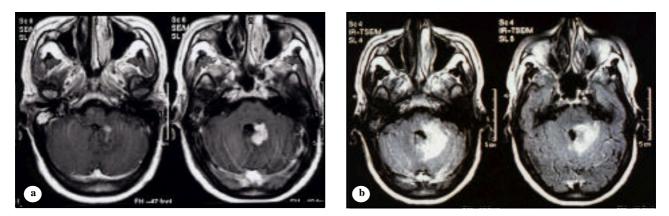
Magnetic resonance imaging of brain showing a) Axial fast flair sequence showing increased signal intensity involving the left middle cerebellar peduncle, extending to the left side of the pons. High signal in the right mastoid bone. b) Axial T1 post contrast injection, demonstrating enhancing lesions in the same areas.
